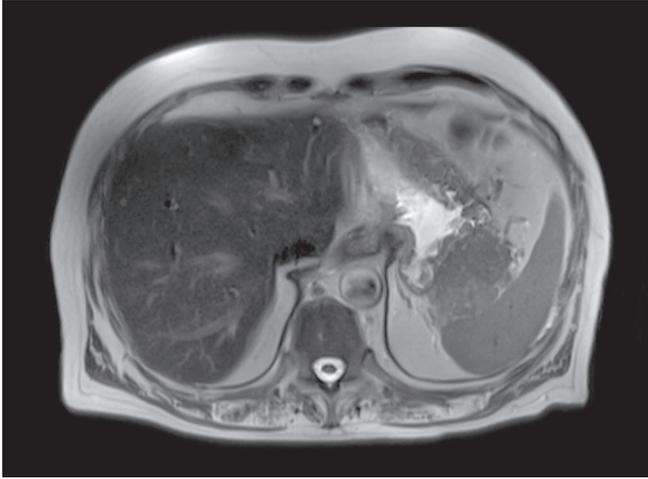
A magnetic resonance imaging (MRI) picture, T2 phase. The close relationship with the stomach and spleen is evident
